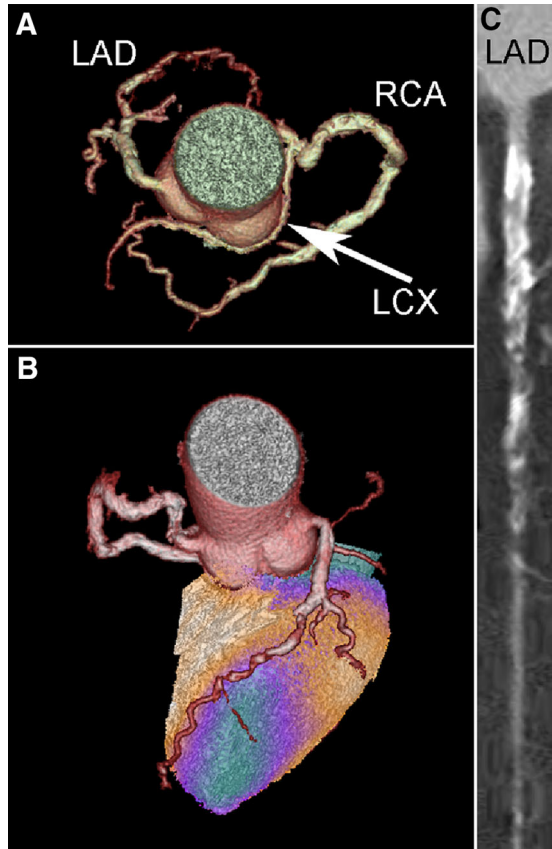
CCTA shows a patient with a benign ACAOS variant and a retroaortic course of the LCX (A). Hybrid CCTA/SPECT-MPI (using the CT attenuation-corrected stress dataset) reveals an anteroapical ischemia matching the perfusion area of the LAD (B). CCTA demonstrates severe coronary atherosclerosis with subtotal stenosis of the middle LAD (C).
